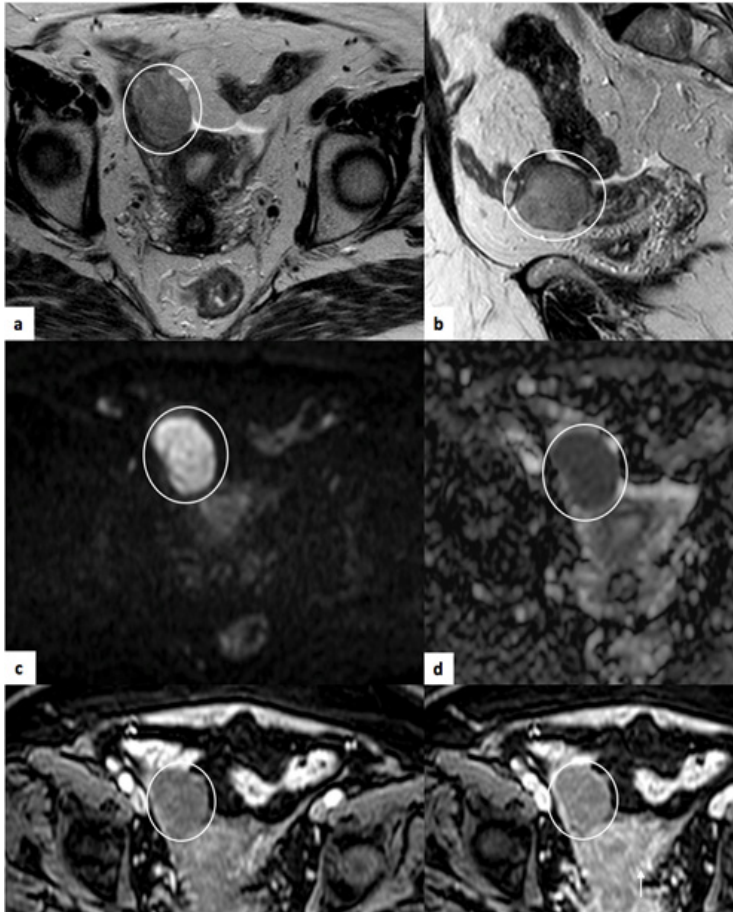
Thecoma of the right ovary. Pelvic MRI of a 69-year-old woman. (a) and (b) correspond to axial and sagittal T2-weighted images, respectively, where a right ovarian lesion is shown, with an intermediate T2 signal (circle). (c) and (d) DWI ($b=1000$) and ADC map, respectively, showing restricted diffusion. On the post-contrast images-axial T1 SPAIR (e) and (f) there is a mild and delayed enhancement of this lesion, inferior to that of the myometrium (arrow). Although the T2 signal is intermediate, which does not correspond to the more typical aspect, the behaviour of the lesion in the dynamic study favours its fibrous nature. The anatomopathological study revealed a thecoma.
